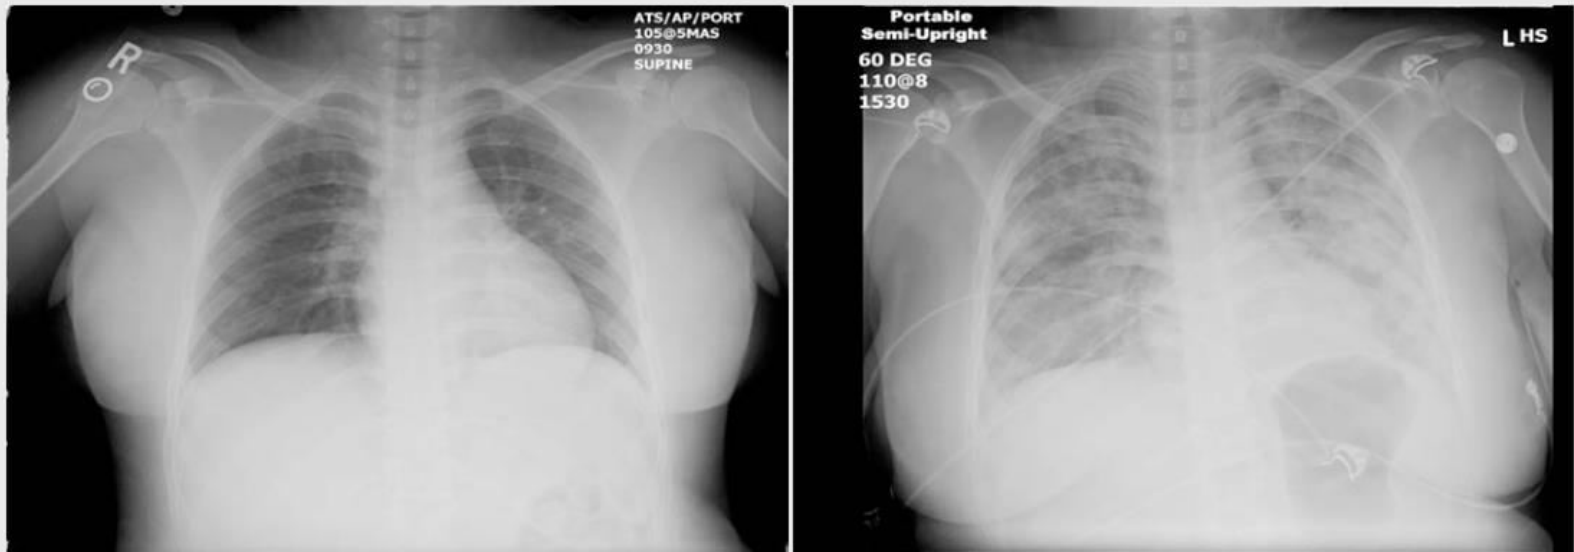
Pre and Post transfusion X-rays of our patient with TRALI. Bilateral Lung infiltrate with pulmonary edema is an essential criteria for the clinical diagnosis of TRALI.
